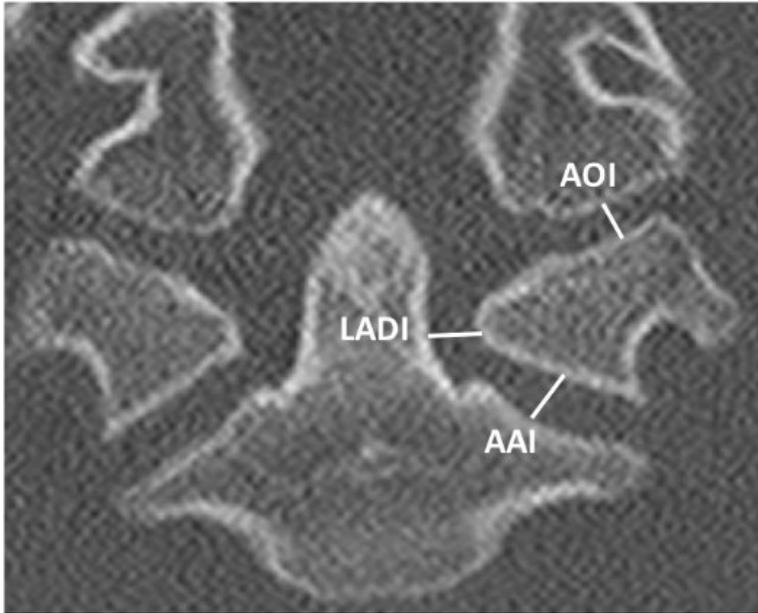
Coronal cervical spine CT image demonstrating LADI, AAI, and AOI measurements
